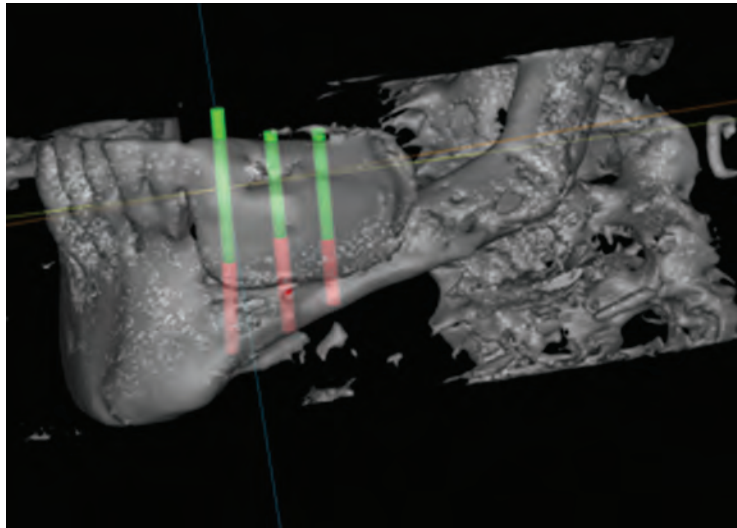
Computerized planning software using reconstructed three-dimensional images from a computed tomography angiogram of the fibula and a computed tomography scan of the mandible shows the desired segment of fibula for reconstruction.
